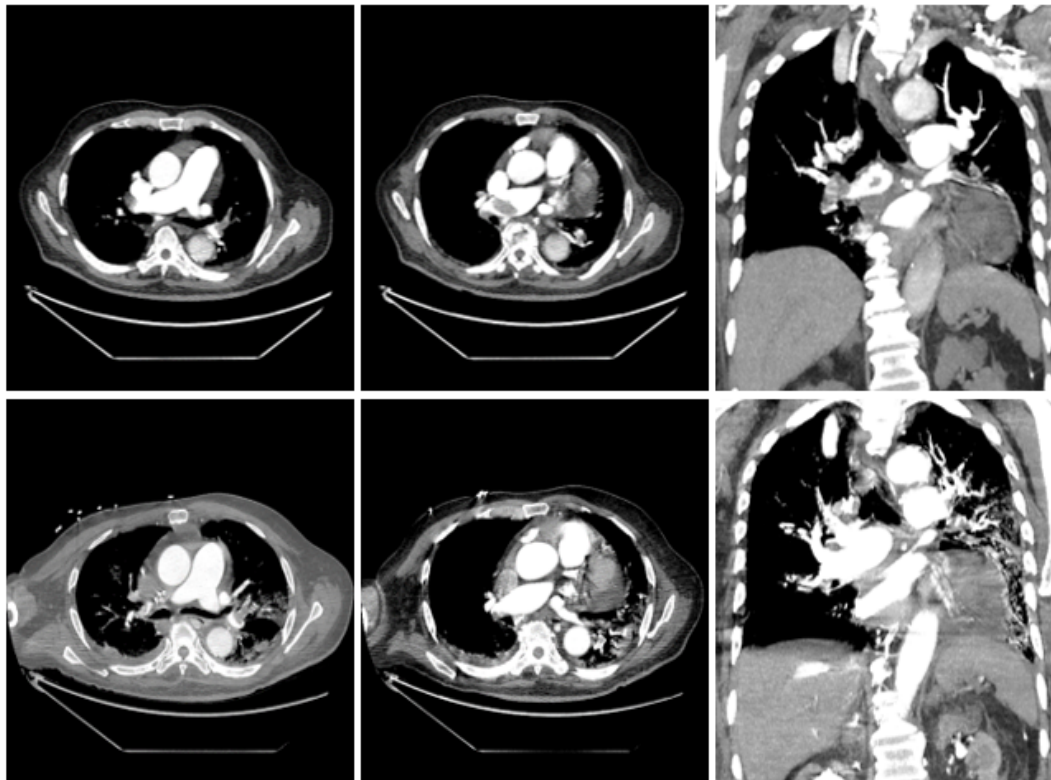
CTA chest before (top row) and after (bottom row) thrombectomy.
